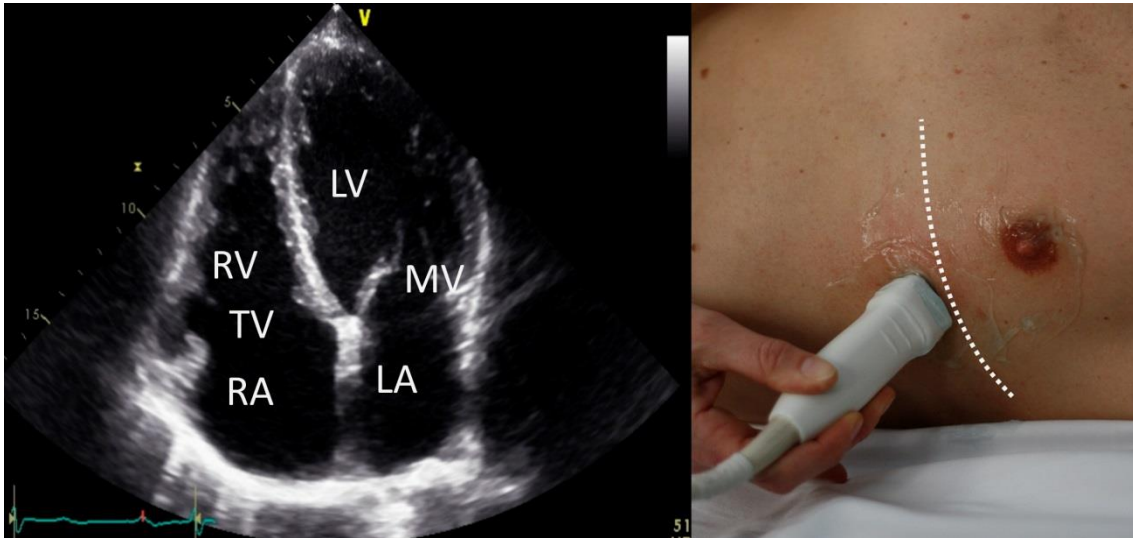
Apical 4-chamber view. RV: Right ventricle; LV: Left ventricle; TV: Tricuspid valve; MV: Mitral valve; RA: Right atrium; LA: Left atrium
